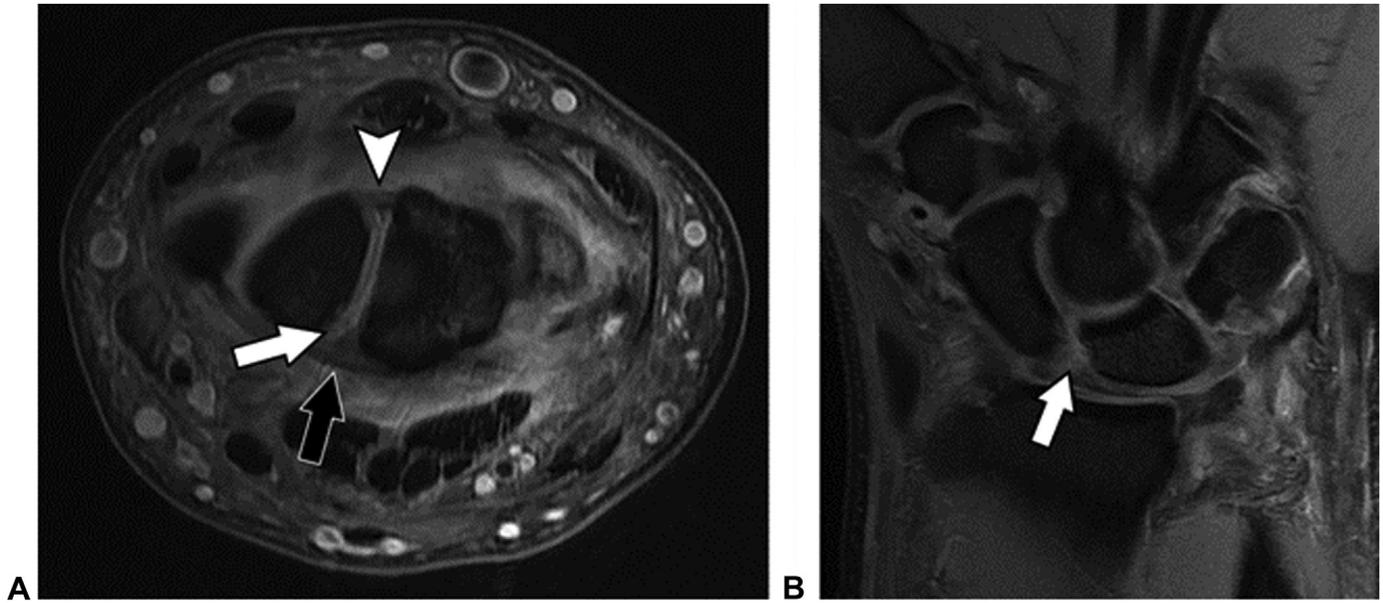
Stage 1 SLIL injury in a 22-year-old professional American football player. The scapholunate interval and angle were within normal limits on static posteroanterior, dynamic clenched fist, and pallateral radiographs. A Axial PDW fat-suppressed MR image shows an intact SLIL dorsal band (arrowhead) and torn SLIL volar band (white arrow), which were confirmed at surgery. A normal long radiolunate ligament (black arrow) courses directly over the torn SLIL volar band and can be mistaken for an intact SLIL volar band. B Coronal PDW fat-suppressed MR image shows partial tearing (arrow) extending to the SLIL interosseus band. (Adapted with permission from Palisch et al¹⁰¹).
